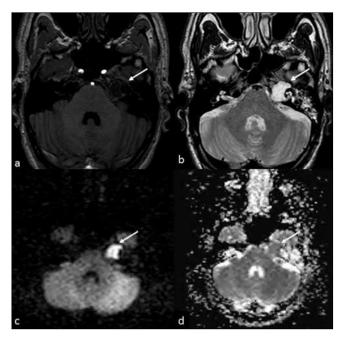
MRI in the axial plane showed a soft-tissue mass in the left petrous apex (arrows) with low signal on T1-weighted sequence A), high signal on T2-weighted sequence B), high signal on DWI C) with corresponding low ADC (Apparent Diffusion Coefficient) D). MRI findings unequivocally confirm the suspicion of PBC.
